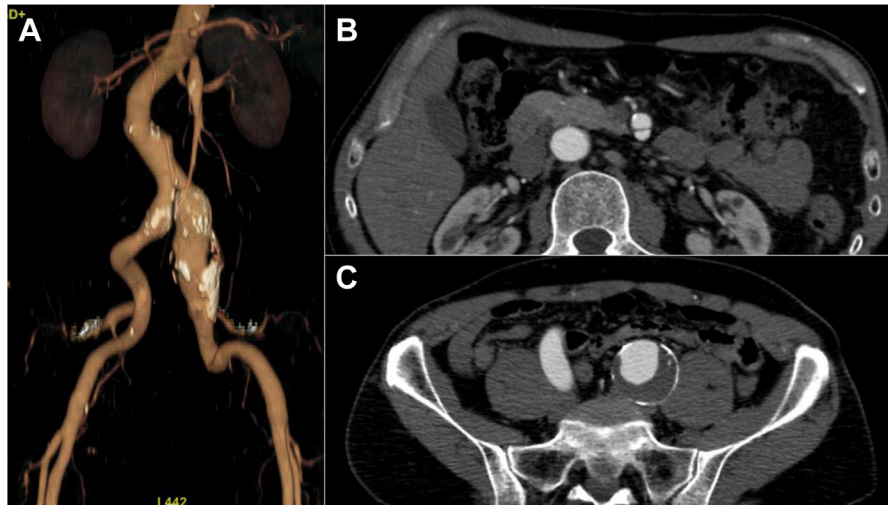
A, Postprocessing three-dimensional image of a computed tomography angiogram of a 62-year-old man with vascular Ehlers-Danlos syndrome (VEDS; *COL3A1*, c.555delT, p.Gly186ValfsTer36, null variant) demonstrating a 40-mm left common iliac artery aneurysm. B, Axial computed tomography image showing a superior mesenteric artery dissection. C, Axial computed tomography image showing a 40-mm common iliac artery (CIA) aneurysm.
